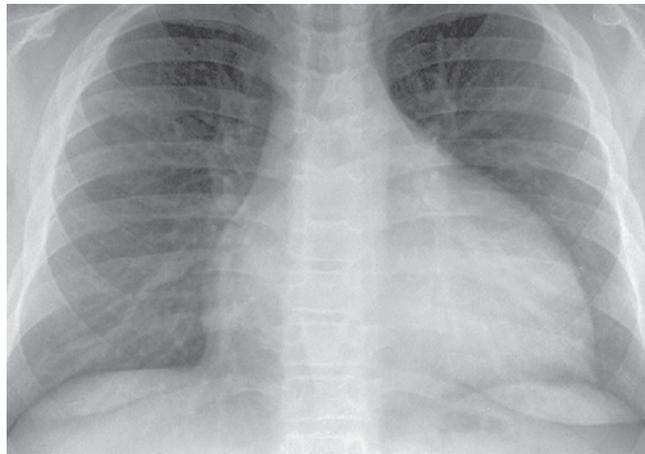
X-ray film shows the cardiomegaly with obtuse cardiophrenic angle, indicating the presence of pericardial effusion
